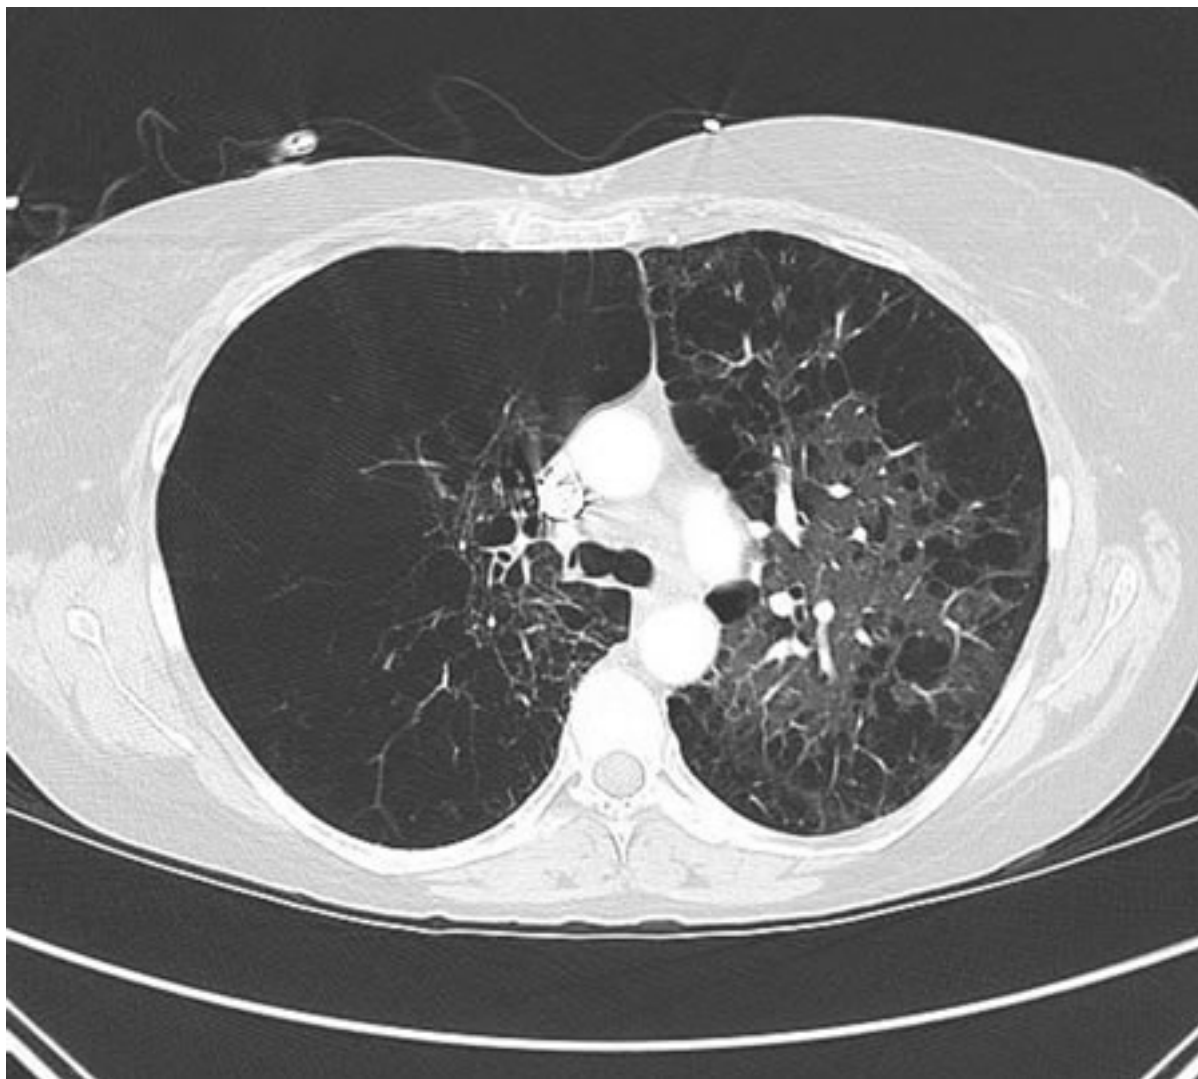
COPD chest CT: hyperinflated lung, emphysematous changes, and increased antero-posterior diameter (barrel chest)
